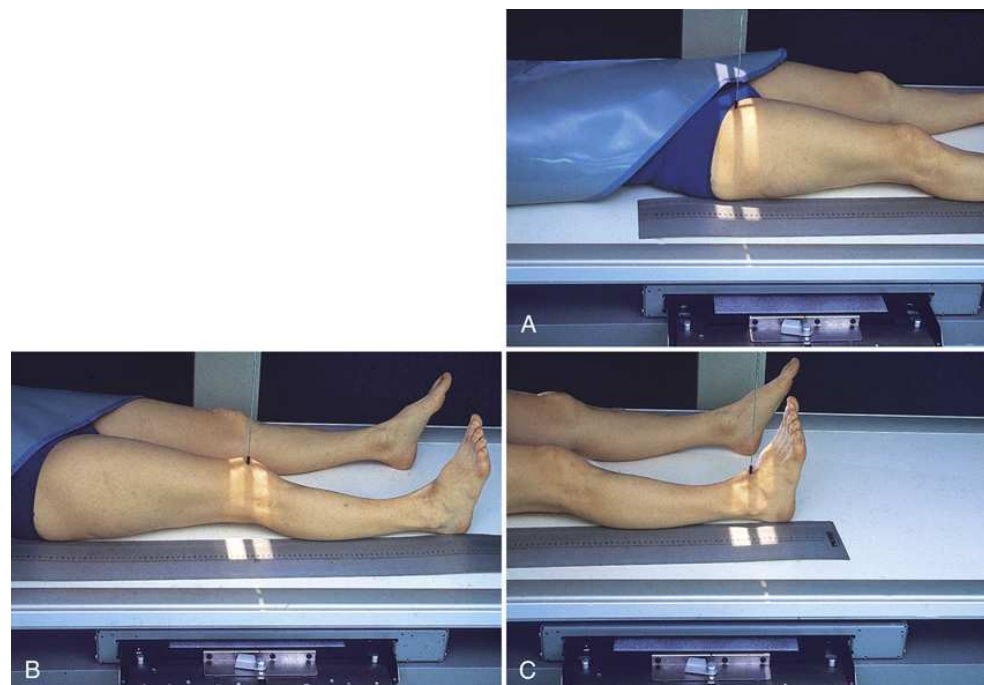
Supine scanogram procedure. Three radiographs are taken. (A) The first is at the level of the hip joints; (B) the second is at the level of the knee joints; and (C) the third is at the level of the ankle joints.
